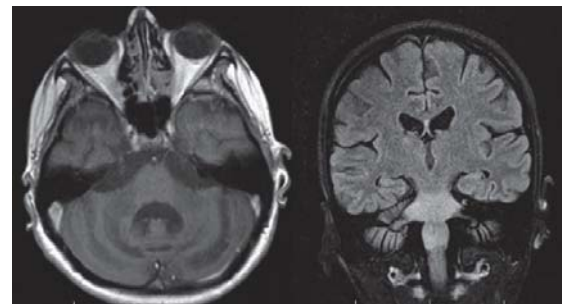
Axial T1 sequence with contrast substance and FLAIR sequence in the coronal plane for the presented case
